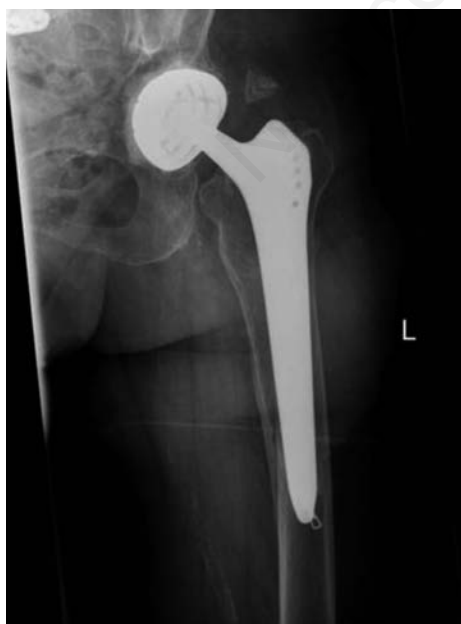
Preoperative X-ray image of periprosthetic femoral fracture Vancouver type B (a.p.).
